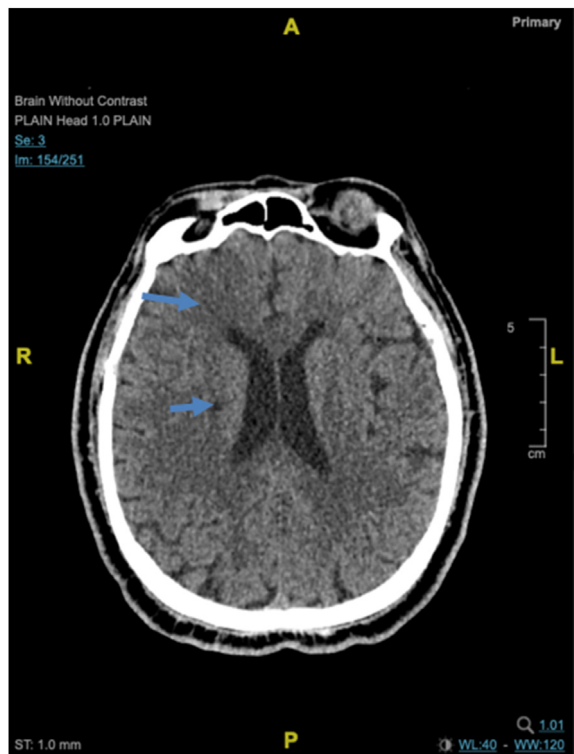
Initial Day 1 Brain CT Scan showing acute ill-defined hypodensity (blue arrows) of right frontal and right corona radiata.
